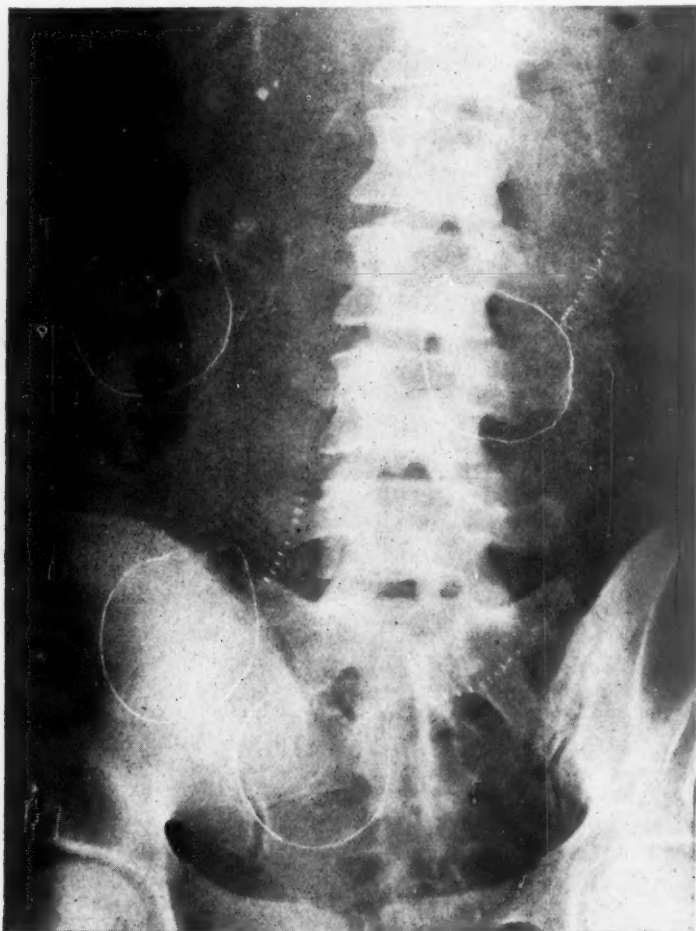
X-ray taken at four and one-half months (retouched).
